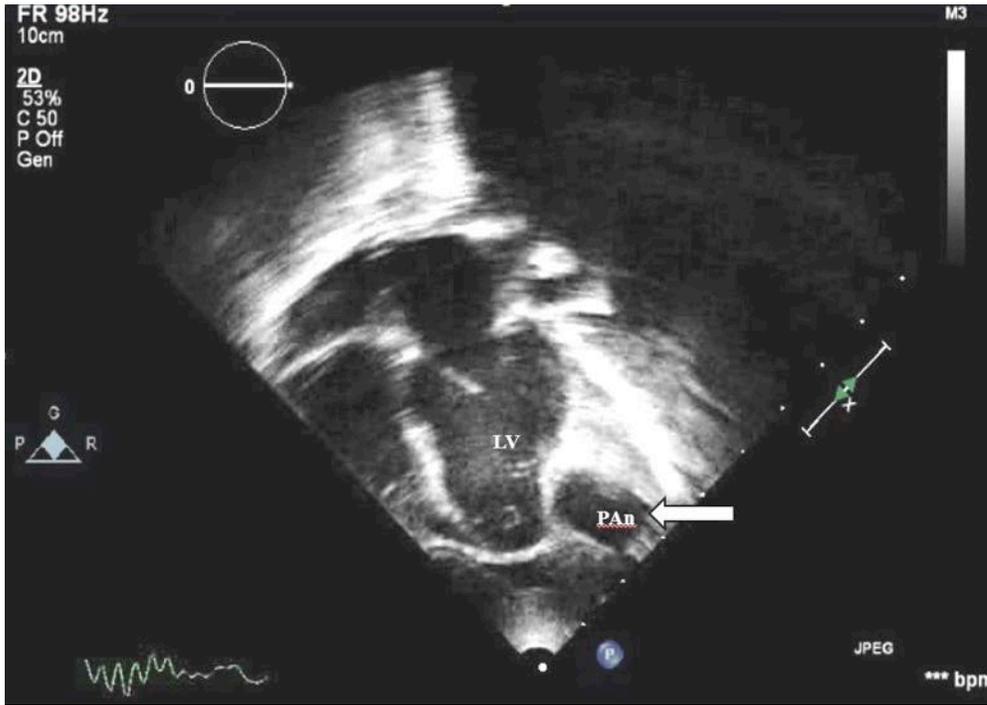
Apical four chamber view in 2-D showing the LV pseudoaneurysm size and location (PAN) (arrow).
